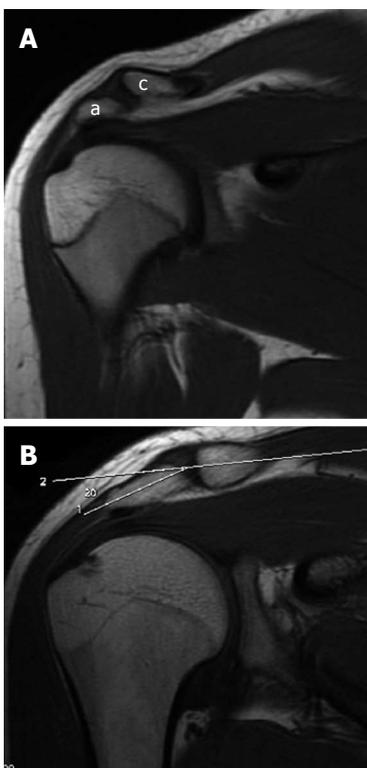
Acromion orientation. A: Coronal oblique T1-weighted image shows low lying acromion (a) in relation to the clavicle (c) at the Acromio-clavicular joint level; B: Coronal oblique T1-weighted image in another patient shows infero-lateral slope of the acromion. The angle between the acromion and the clavicle is tilted by 20 degrees.
